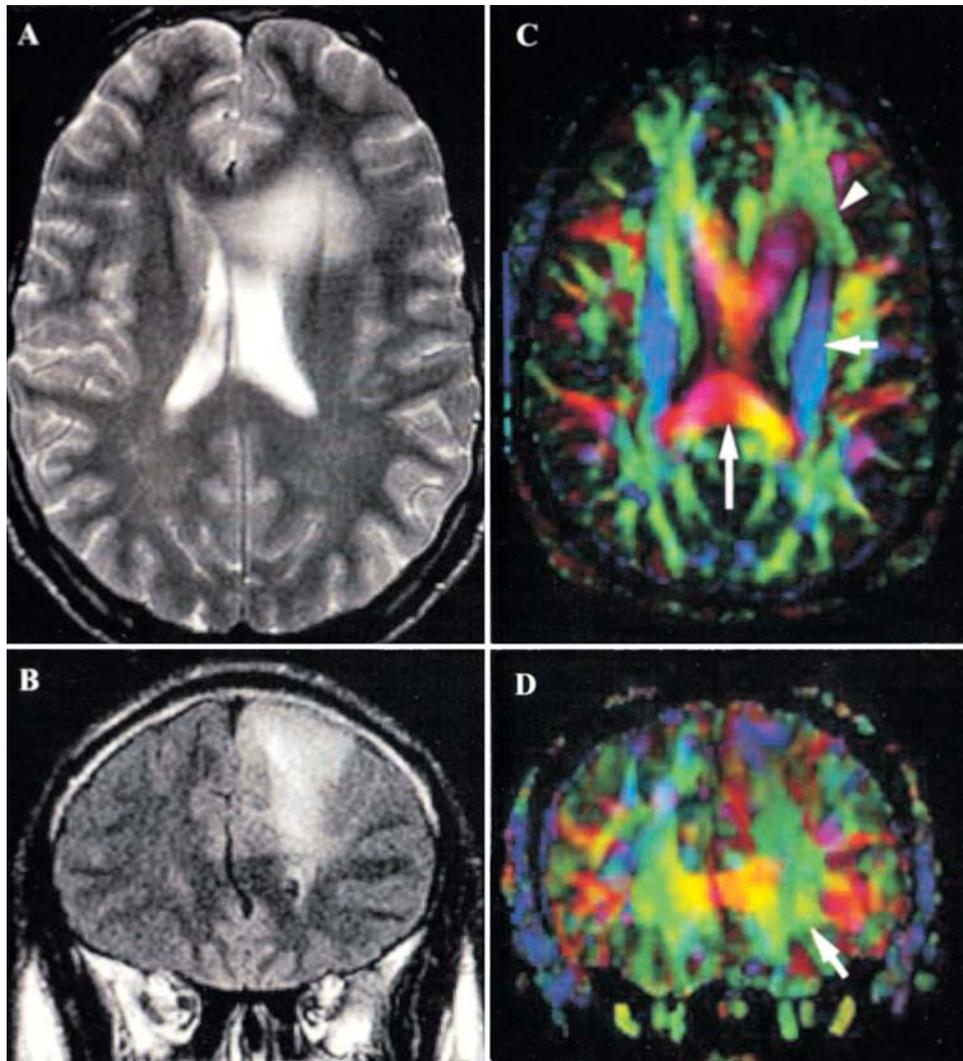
Case 2. Tumor invasion of white matter tracts in a patient with an oligodendroglioma located in the left frontal lobe. A: An axial T₂-weighted MR image obtained during the preoperative planning period. Diffuse signal changes appear throughout the white matter pathways of the left frontal lobe. B: A coronal contrast-enhanced T₂-weighted FLAIR MR image demonstrating the same signal changes in the left frontal lobe, involving white and gray cortical matter. C and D: The directions of white matter pathways are color coded in these DT images: green, anterior/posterior; blue, inferior/superior; and red, right/left. C: An axial DT image corresponding to the same level as the image in A. The fiber pathways of the corona radiata in blue (*short arrow*), arcuate fasciculus in green (*arrowhead*), and corpus callosum in red (*long arrow*) appear in the same anatomical relationship, compared with their corresponding pathway in the contralateral hemisphere. D: A coronal DT image at the level of the genu of the corpus callosum corresponding to the image in B. Note the intact position of the associated white matter tract (*arrow*) in the left frontal lobe in a region invaded with neoplastic cells.
